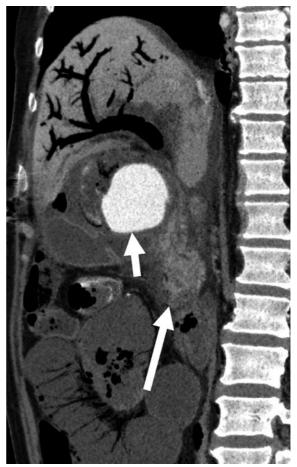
Transmural small bowel infarction due to hemorrhagic shock following massive GI bleeding 7 weeks after biliodigestive anastomosis for pancreatic carcinoma in a 56-year-old male, coronal reformatted contrast-enhanced CT. The bleeding source is a large pseudoaneurysm of the hepatic artery (*short arrow*), contrast medium extravasation into the biliodigestive anastomosis (*long arrow*). Absent contrast enhancement and pneumatosis of the terminal ileum, portal venous gas in the liver. The formation of the pseudoaneurysm is secondary to postoperative visceral inflammation adjacent to the arterial wall. Such pseudoaneurysms are prone to rupture
